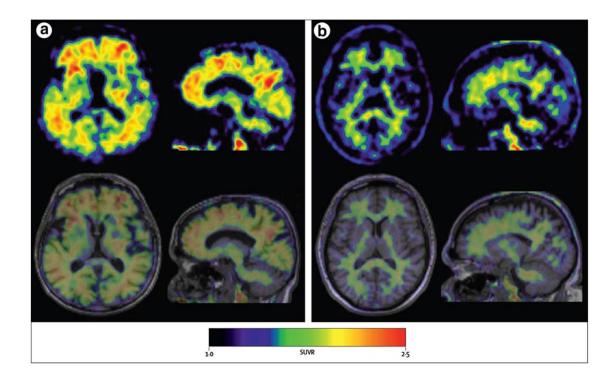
¹⁸F Florbetaben to predict cerebral Aβ burden. PET images (upper) and PET/MRI (lower) show a) AD dementia patient and b) Healthy control. From Sabri, *et al.* ⁴⁶
